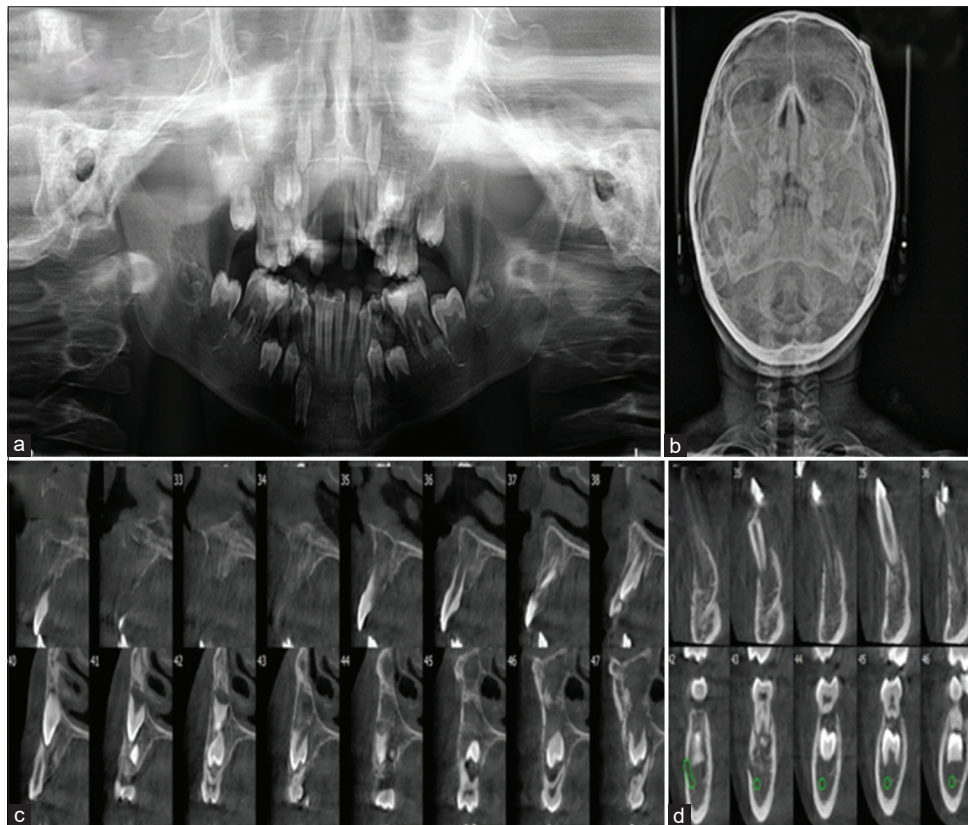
(a) Orthopantomogram showing loss of cortication of the inferior alveolar canal, generalized bone loss, and loss of lamina dura with displacement of developing molars. (b) Paranasal sinus view showing haziness of the right maxillary sinus. (c and d) cone beam computed tomography showing cortical plate destruction, loss of lamina dura, and involvement of developing tooth follicles
